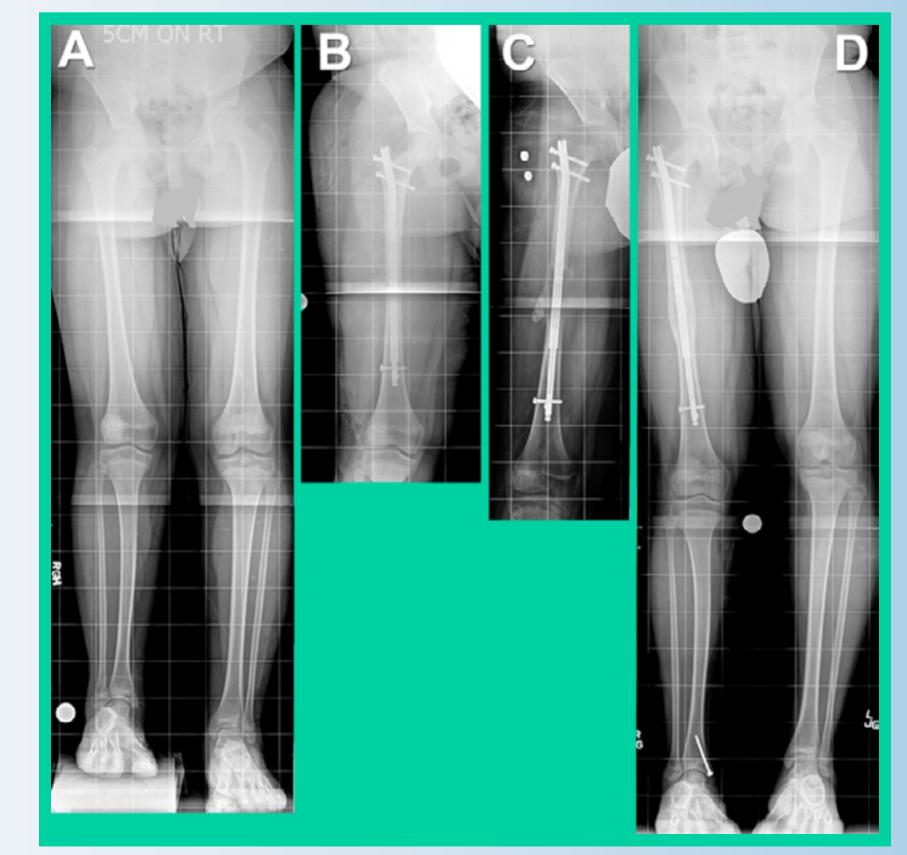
Twelve-year-old boy diagnosed with congenital femoral deficiency and fibular hemimelia. Right limb is 5 cm shorter than the left limb. BMI percentile is 98%. A, Preoperative AP view full length standing radiograph. B, Immediate postoperative AP view radiograph of the right femur. C, AP view radiograph shows distraction is completed. D, AP view full length standing radiograph shows the fully consolidated femur. Lengthening goal was achieved.
